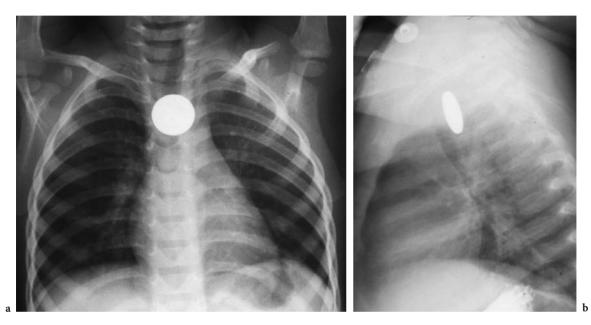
Coin en-face on AP radiograph, thus located in the esophagus as confirmed on the lateral view
